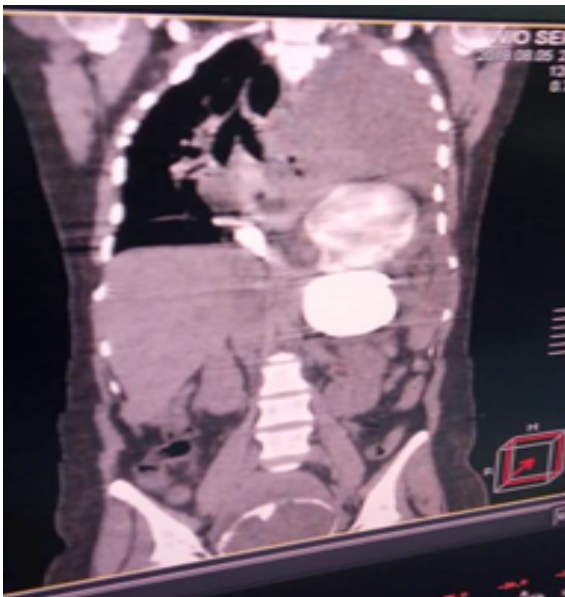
CE CT Scan chest/abdomen showing paraesophageal hernia with gastric volvulus
